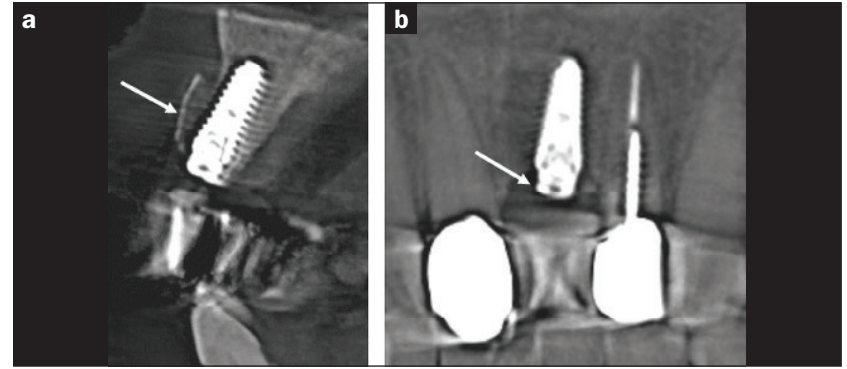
The postoperative CBCT scan: (a) A cross section after graft augmentation shown with the 2 mm flat abutment and the i-Gen titanium membrane. (b) Tangential radiograph of the site following implant placement.
